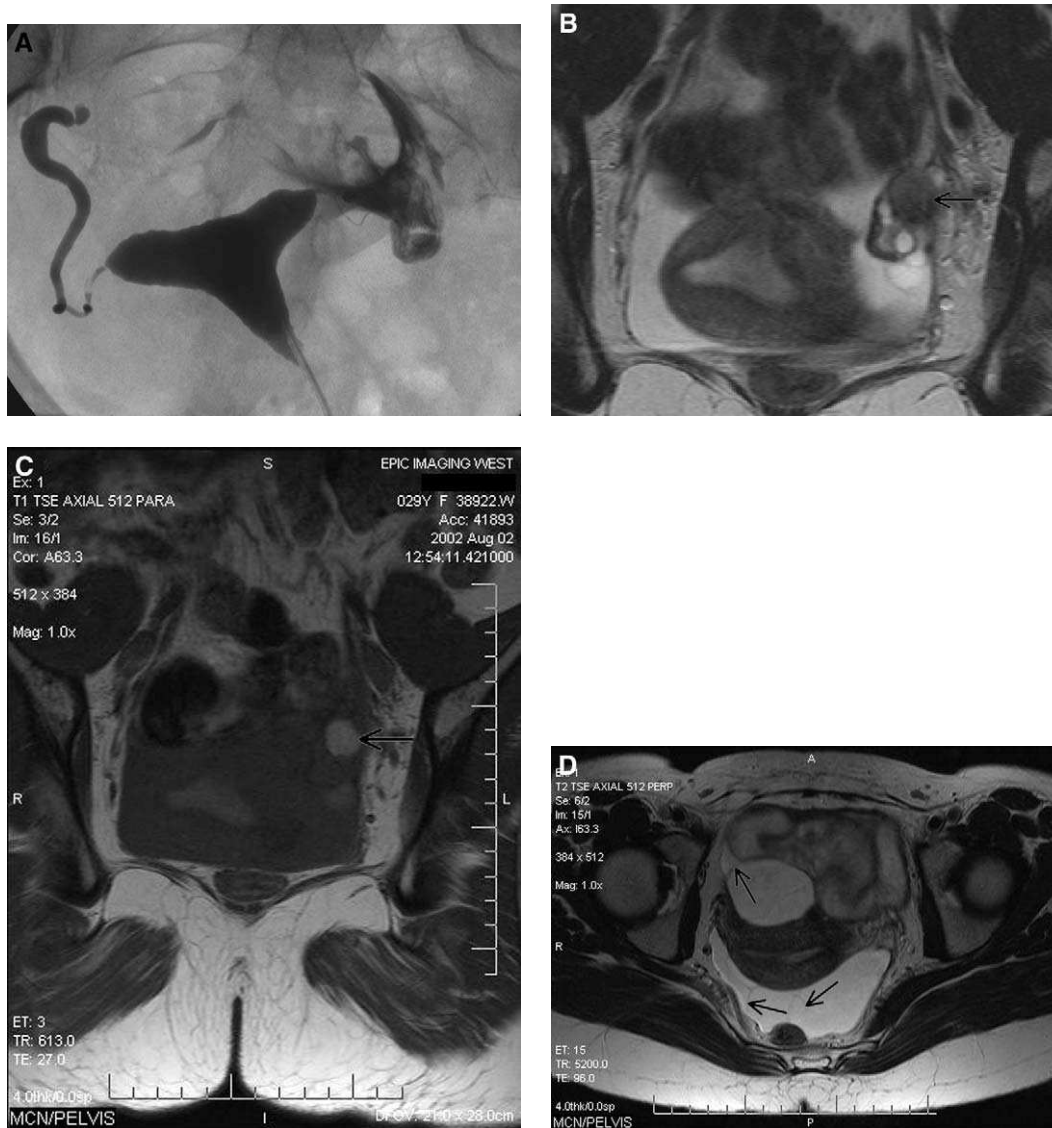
A 29-year-old woman with infertility. (A) Hysterosalpingogram demonstrates occlusion of the right tube in the proximal ampullary portion and tortuosity of the left tube, which is patent. MR imaging demonstrates a left ovarian endometrioma, which is low signal on T2-weighted images (arrow) (B) and high-signal on T1-weighted images (arrow) (C). (D) T2-weighted MR imaging demonstrates adhesions (arrows) that explain the tubal findings.
